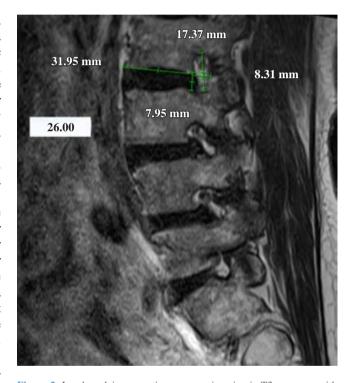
Lumbar plain magnetic resonance imaging in T2 sequence with sagittal view. Combined measurement of foraminal height and width, inferior endplate, index of foraminal width/inferior endplate with a result of 26%, and measurement of posterior disc height.
